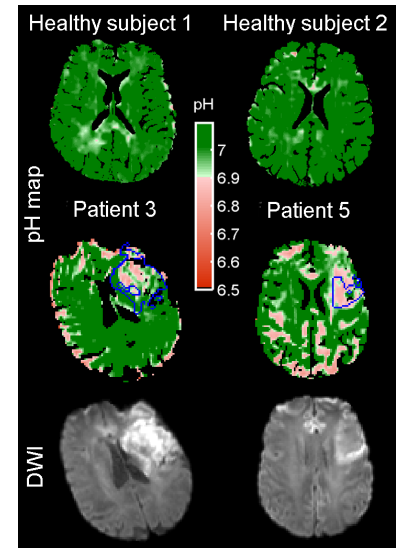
pH maps of healthy subjects and representative patients generated using the relationship in Fig. 1b); DWI ($b = 1000$) of patients are plotted directly below their respective pH map.
